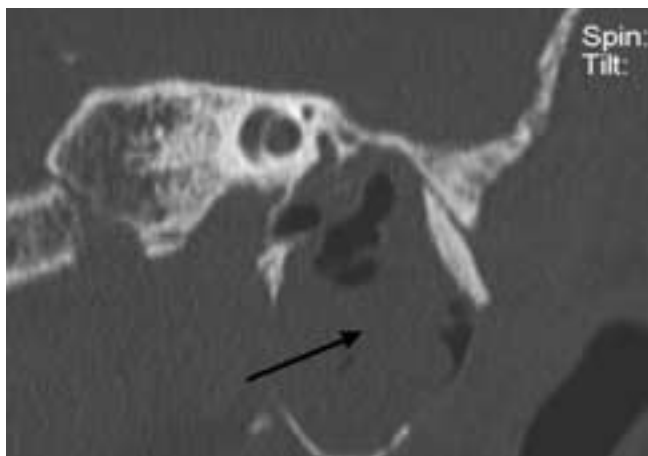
EAC atresia with cholesteatoma. Coronal CT image showing a large cholesteatoma expanding the EAC and middle ear cavity (black arrows) in a patient with EAC atresia. A spontaneous fistula formed between the cholesteatoma and the skin (not shown).
